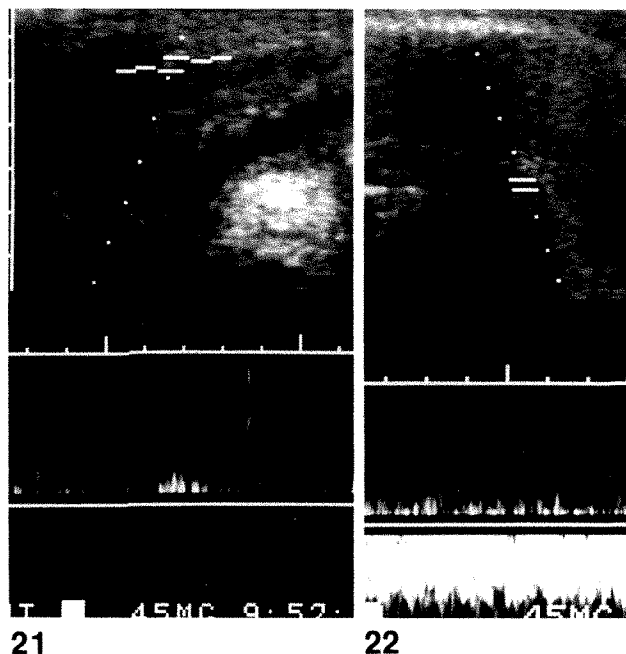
Severe arterial insufficiency. Doppler signal of right cavernosal artery after papaverine injection shows minimal flow (peak velocity, 20 cm/sec).
